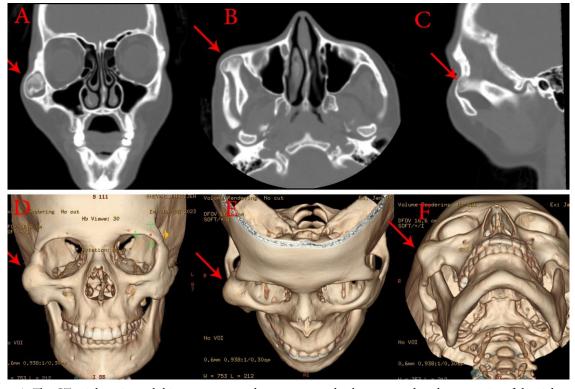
A: The CT axial section exhibits an osseous enlargement seamlessly connected to the extremity of the right coronoid process. B: The CT coronal section displays the elongation of the right coronoid mass along the inner surface of the zygomatic arch. C: The sagittal section of the CT scan reveals an outward growth of the left coronoid process. D,E,F: 3D view of zygomatic arch deformity due to OC
